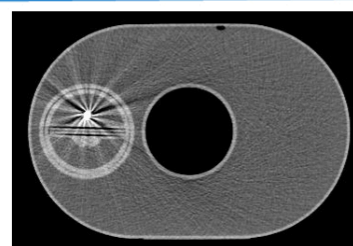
CT slice through showing the body oval, target and film insert
